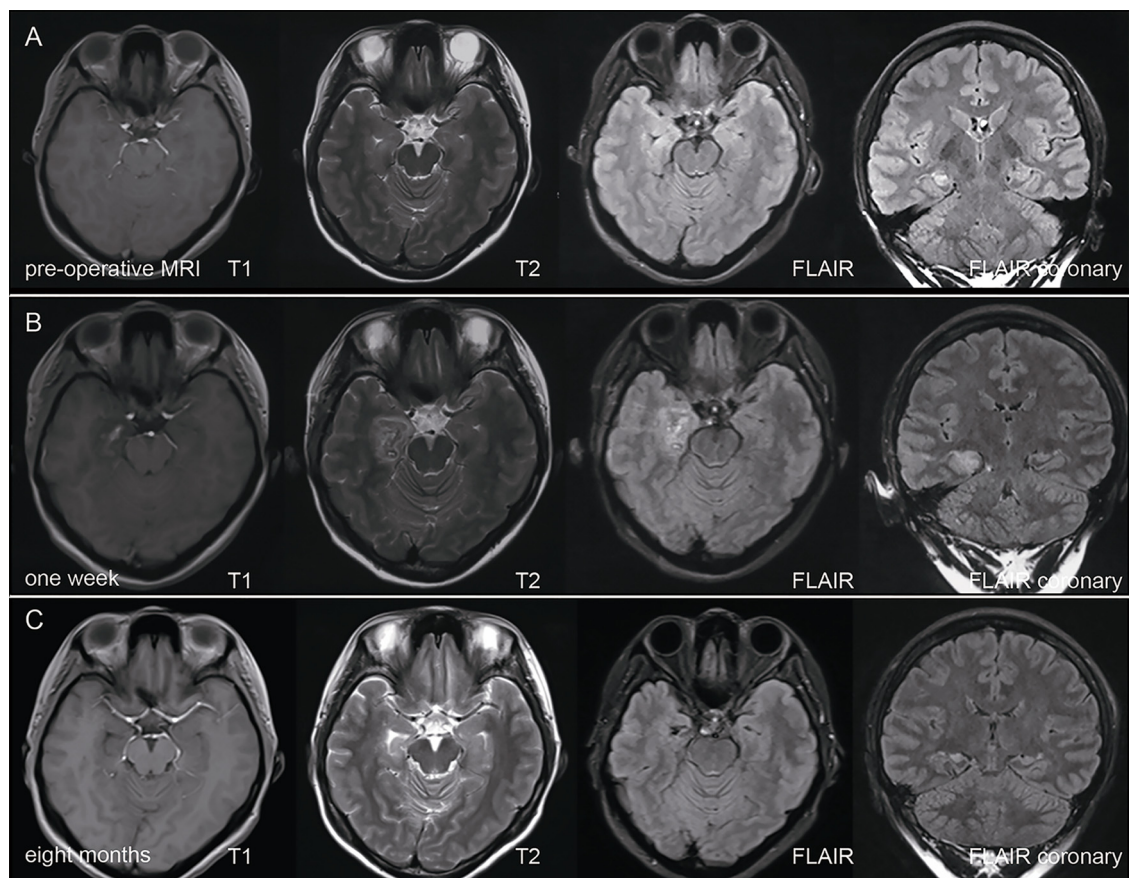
Pre- and post-operative MRI.
